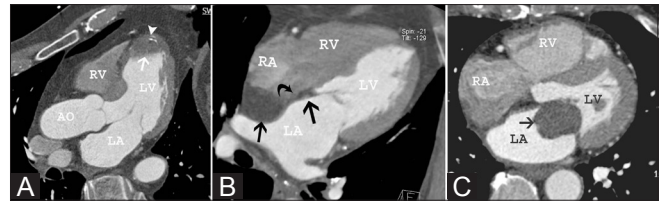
(A–C): Cardiac masses. Three-chamber reformatted CT image (A) shows a layered thrombus in the left ventricular apex (arrow); there is an associated linear band of calcification (arrowhead). Four-chamber reformatted CT image (B) shows a fatty mass in the interatrial septum (straight arrows) with sparing of the fossa ovalis (curved arrow); this is characteristic of lipomatous hypertrophy. Axial CT scan (C) shows a well-defined mobile mass (arrow) attached to the anterior mitral valve leaflet, consistent with myxoma
